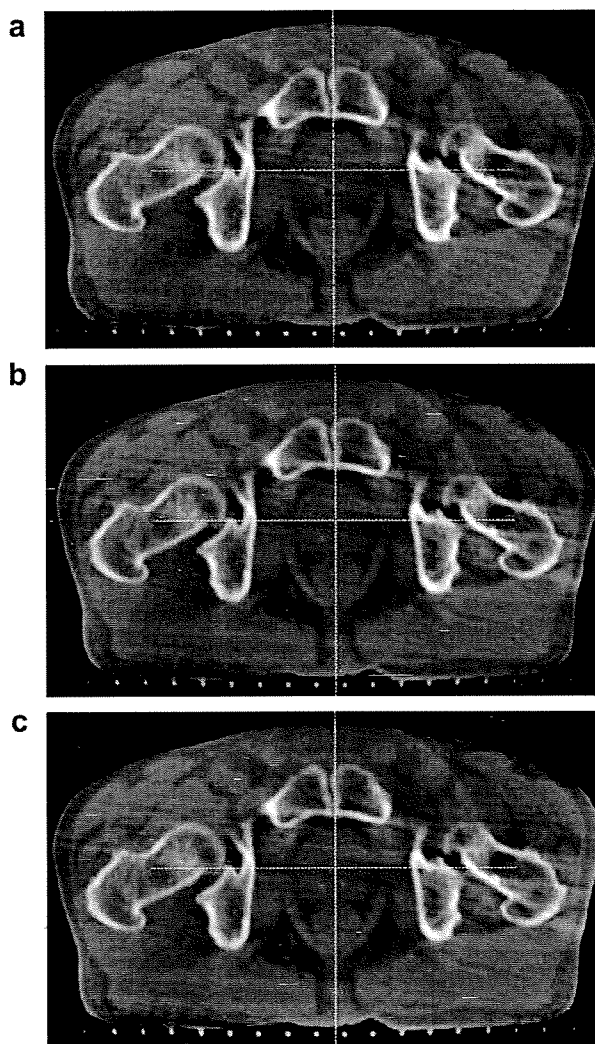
kV CBCT axial images of a prostate cancer patient: (a) immediately before treatment after registration, (b) during VMAT delivery, and (c) immediately after treatment. The cross lines indicate the isocenter.
